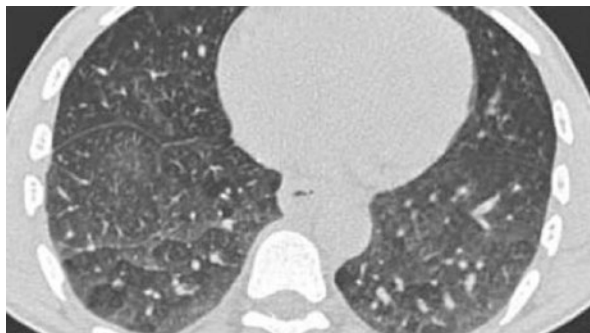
Before lung transplant. (a) Chest x-ray showing idiopathic pulmonary fibrosis showing reticular-nodular changes and traction bronchiectasis. (b) High resolution CT images showing changes consistent with idiopathic pulmonary fibrosis. Imaging of the lung parenchyma should include views obtained with the patient lying prone to reduce gravitational effects on lower-lobe lung density. Overall there is a peripheral predominance with prominent irregular septal thickening (arrowhead), sub pleural honeycombing (asterisk), and a dilated airway, representing traction bronchiectasis (arrow). Open-lung biopsy confirmed pathological changes typical of usual interstitial pneumonia
